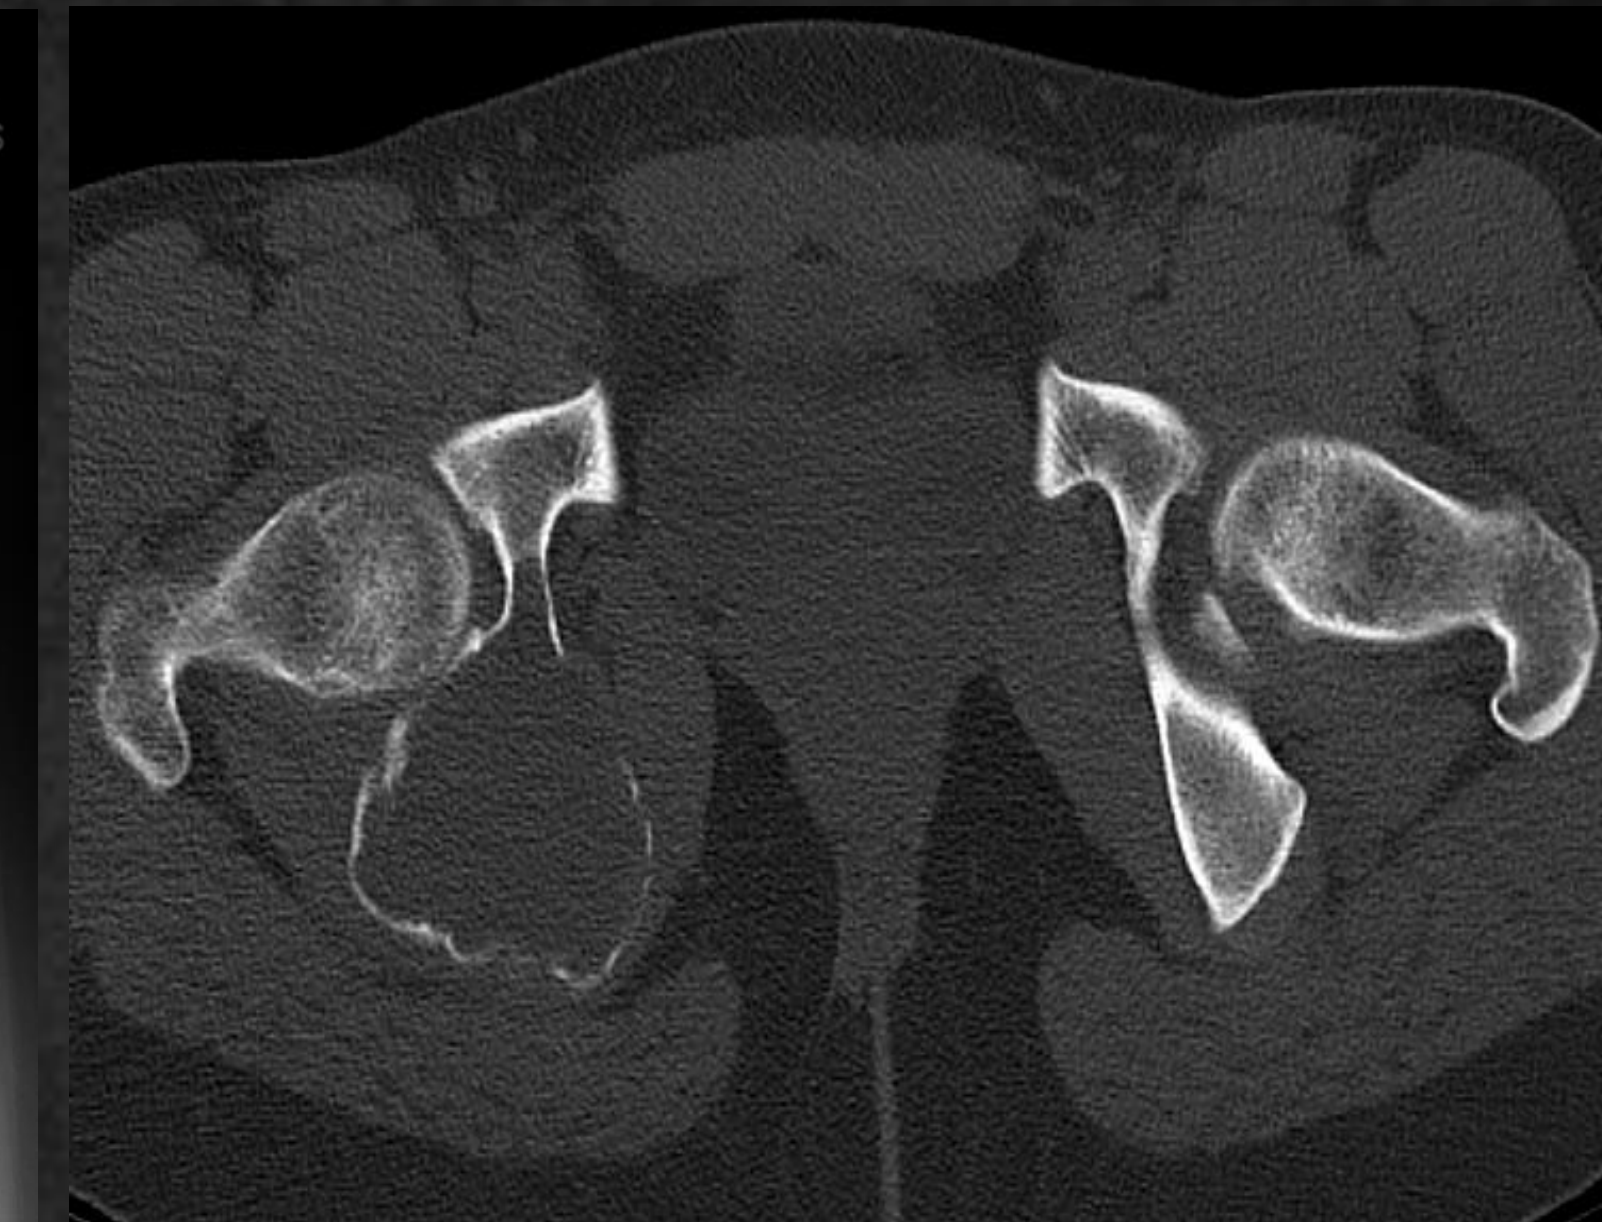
Axial CT shows expansile ABC
